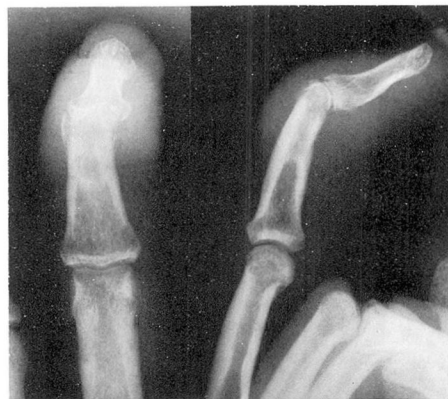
Roentgenograms of the right middle finger of a patient with Hodgkin's disease. They show soft tissue swelling, periosteal reaction, and erosion of the bony cortex of the middle phalanx with narrowing of the joint space. Material aspirated from the infected joint space yielded *Mycobacterium kansasii* and *Cryptococcus neoformans*.
